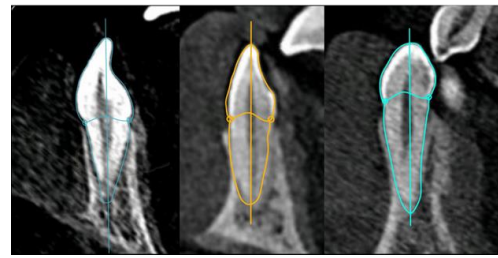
Superimposition of tooth cross-section outline in CorelDraw on CBCT images
